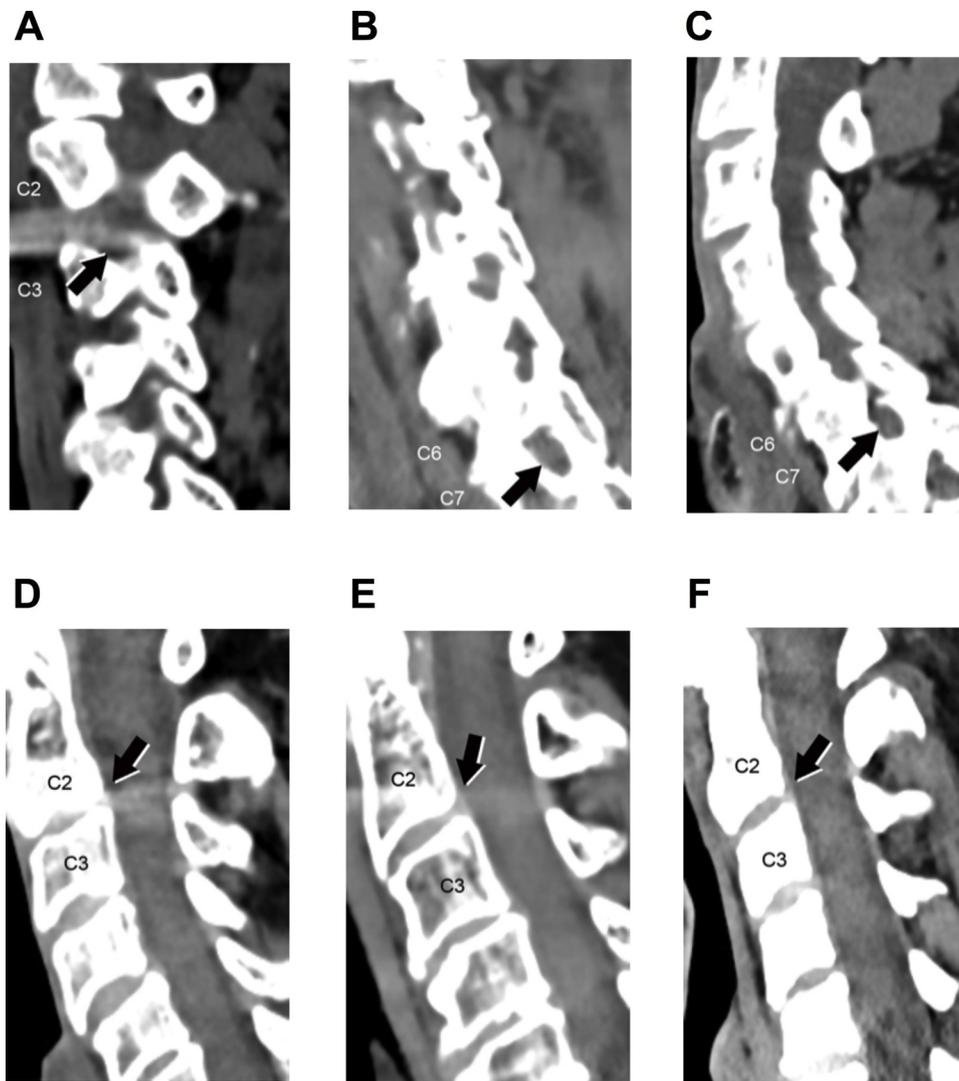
Assessment of morphological characteristics of foramina spinal nerve and intervertebral disc at C2/3 and C6/7 using sagittal reformatted soft-tissue window CT images with the following criteria: not visible (arrow in A and D), visible but not analyzable (arrow in B and E) and clearly visible (arrow in C and F).
